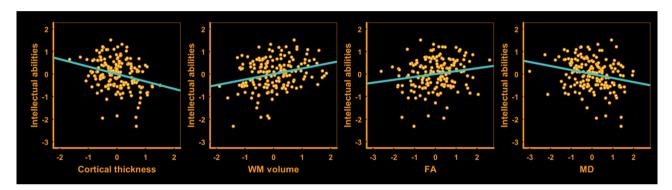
Relationships between intellectual abilities and brain structure. Standardized partial regression plots based on the multiple regression analyses on intellectual abilities with sex, age and the separate MRI measures as covariates (see Table 2). All variables are shown as z-scores.
